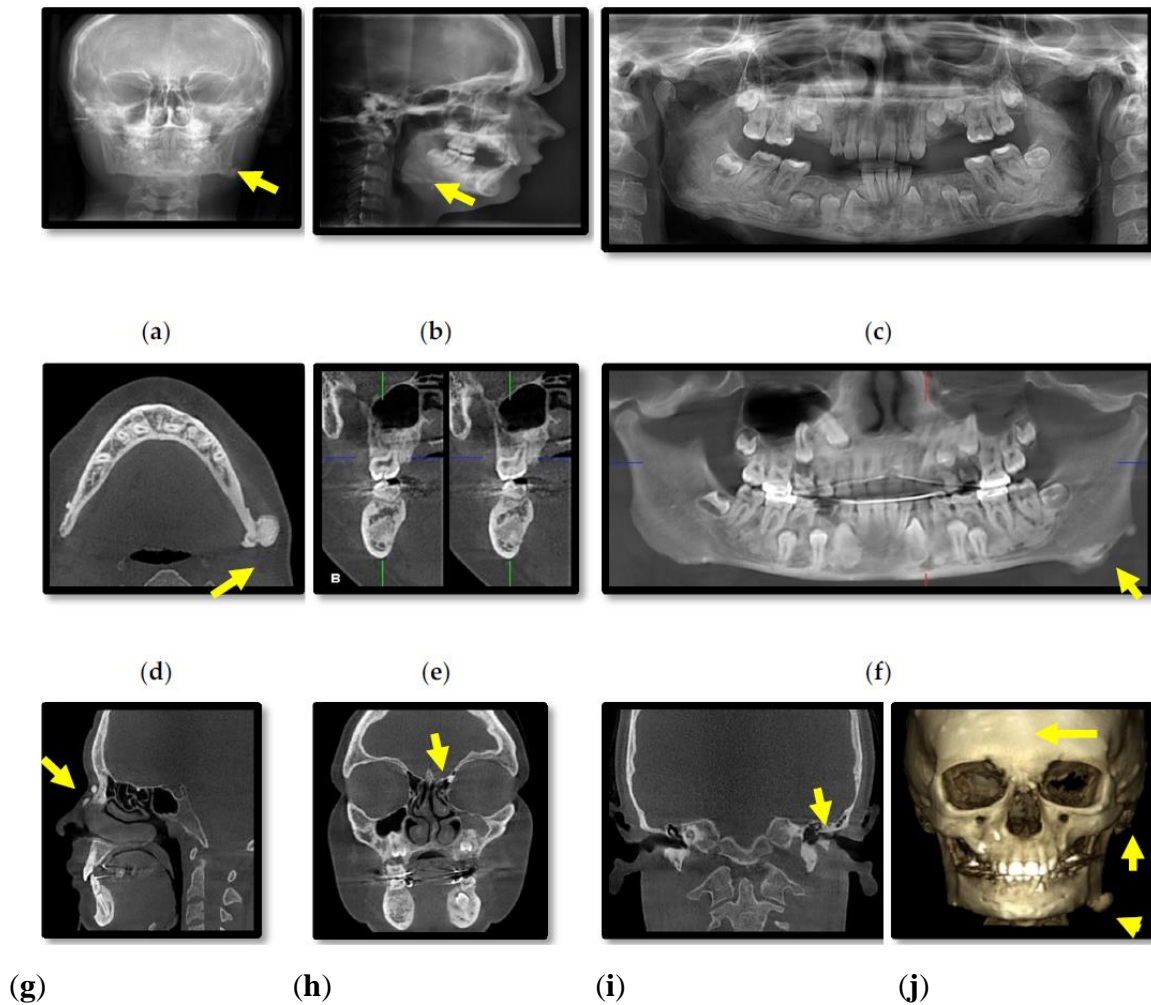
Patient III.1. Cephalometric (a,b) and panoramic (c) radiographs; Cone-beam computed tomography (CBCT) with axial (d), cross-section (e), panoramic (f), sagittal (g), coronal (h,i) views and 3D reconstructions of bone tissue (j).
